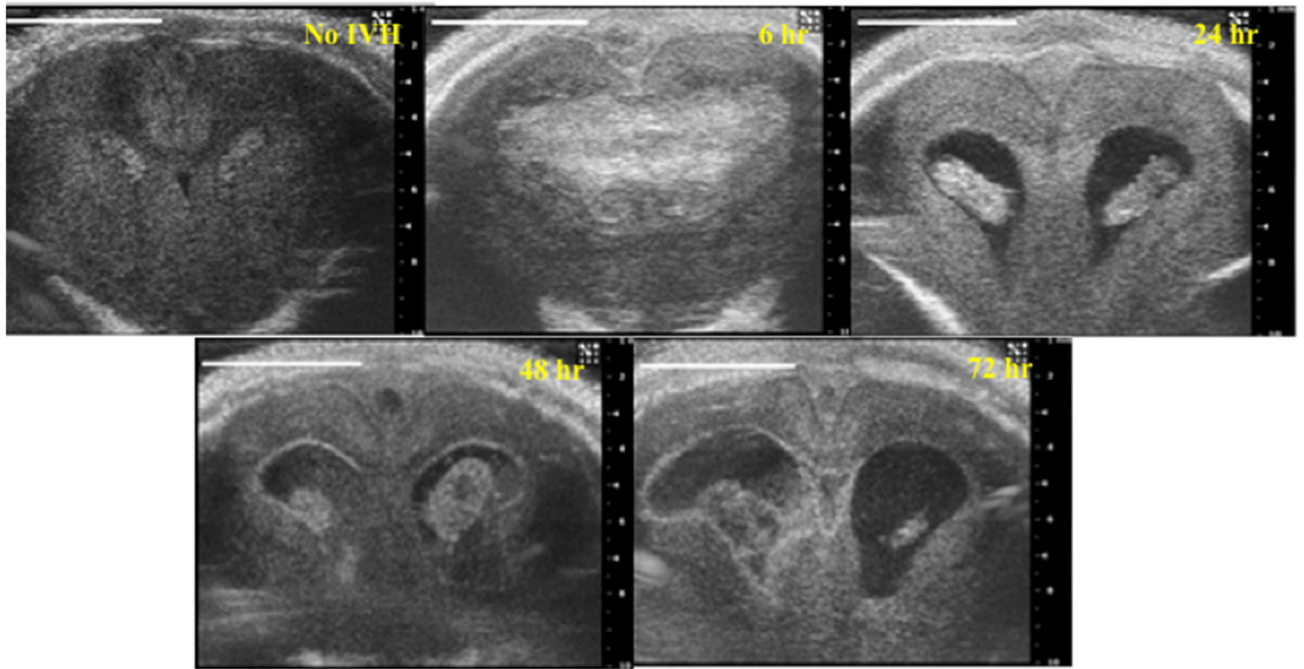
Diagnosis of IVH by HFU. The hemorrhage appears already at 6 hours after induction of IVH by *i.p.* injection of glycerol. IVH develops further into PHVD over 72 hours. Reprinted from "High-Frequency Ultrasound in the Evaluation of Cerebral Intraventricular Haemorrhage in Preterm Rabbit Pups", by Sveinsdottir S, Cinthio M, Ley D. *Ultrasound in Med Biol* 2012; 38: 423-431. Copyright Elsevier 2012 (114).
